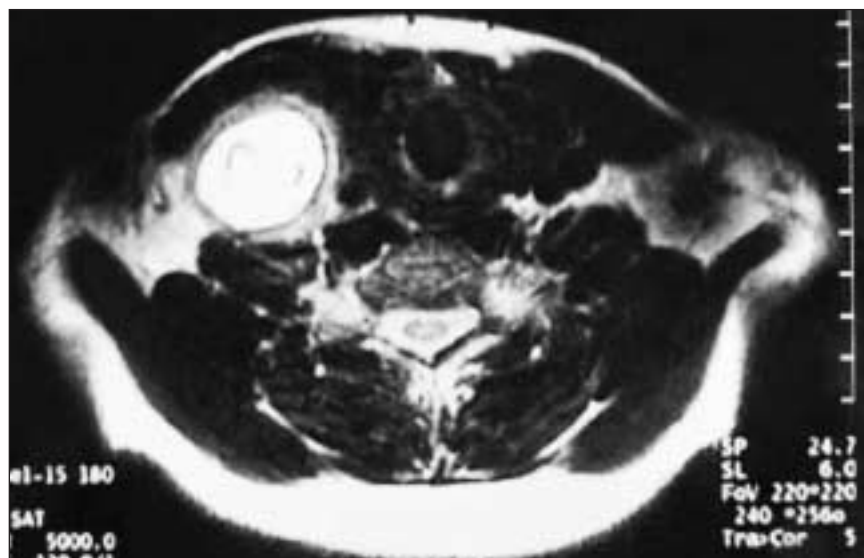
Magnetic resonance imaging showing the cystic mass in cervical soft tissue.
